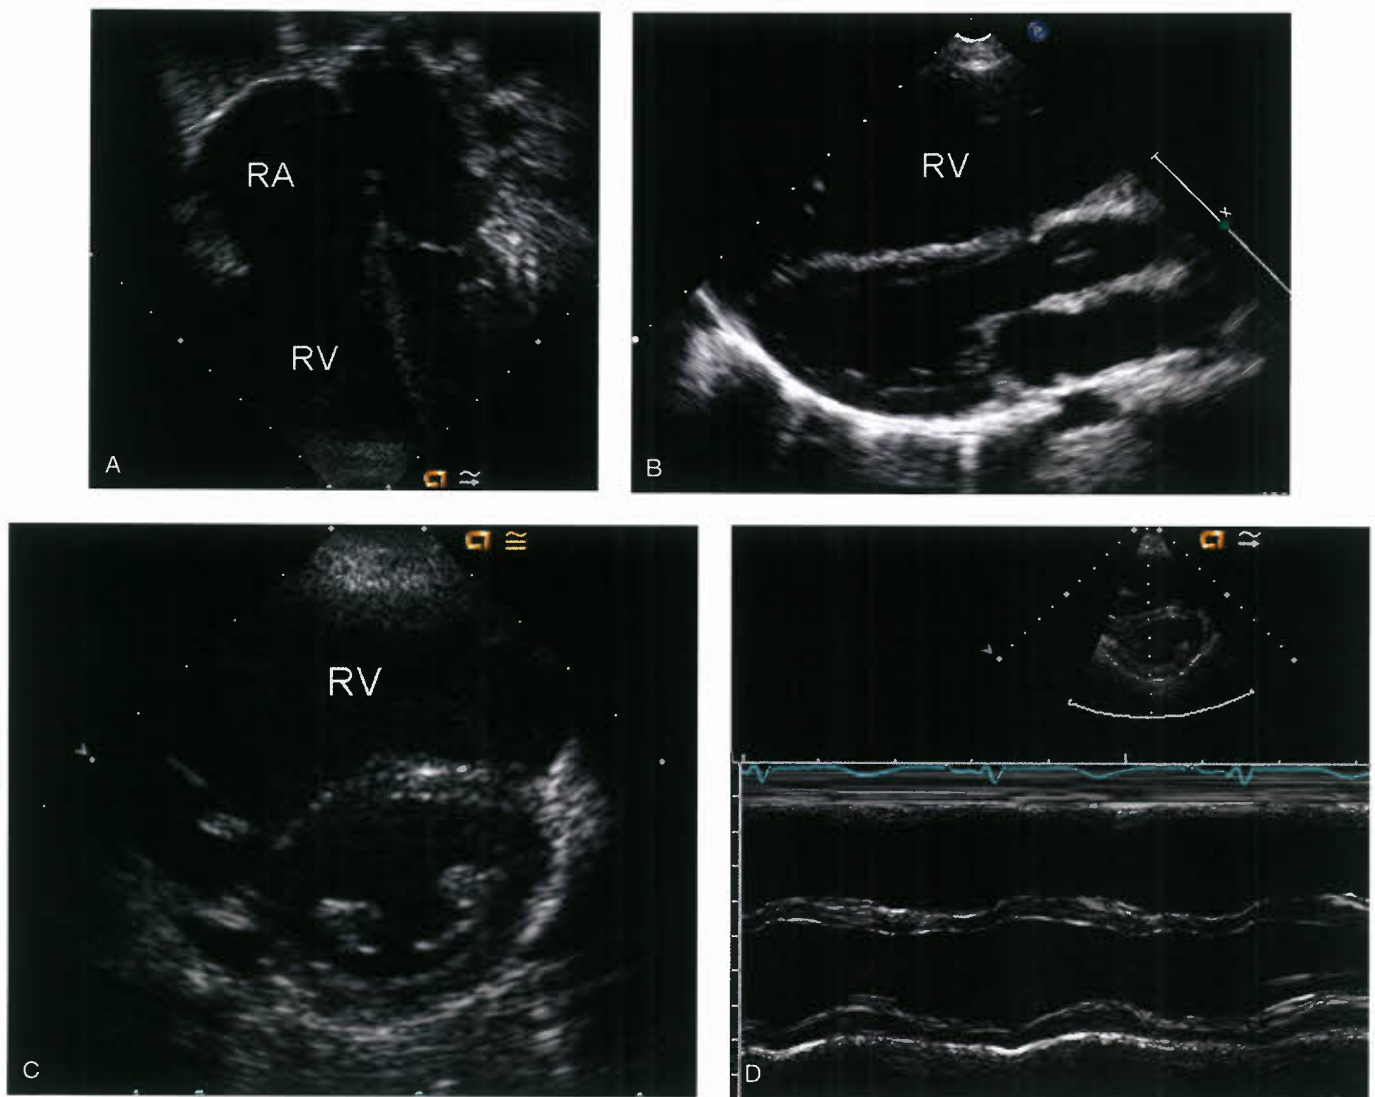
Severe right atrial (RA) and right ventricular (RV) dilation seen in a patient with large secundum ASD: A: apical view; B: Parasternal long-axis view; C: Short-axis view. D: M mode showing RV dilation and paradoxical motion of the interventricular septum.
